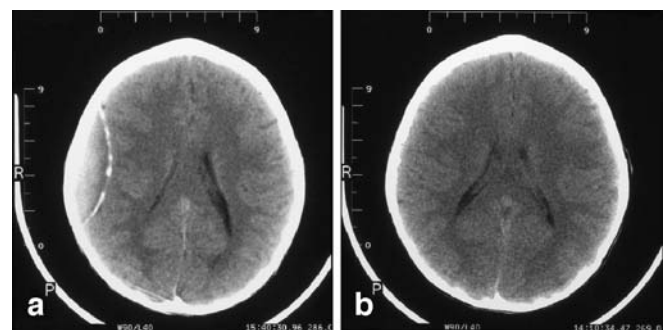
a CT 18 days after diagnosis of an EDH under conservative management with dural calcification (patient number 9) and b CT 6 weeks later showing that the calcification has completely resolved
